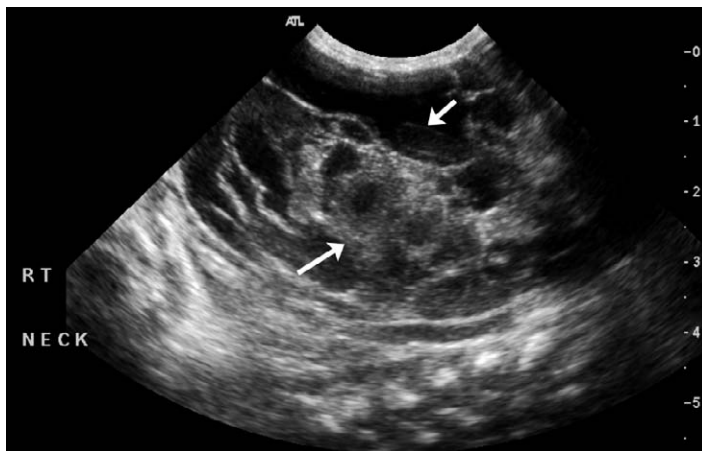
Sonographic longitudinal view of the right neck. A large mass is seen (arrows), insinuating around the normal structures of the neck. The mass is partially anechoic (cystic) and partially shows mixed echogenicity with septae of variable thickness.
